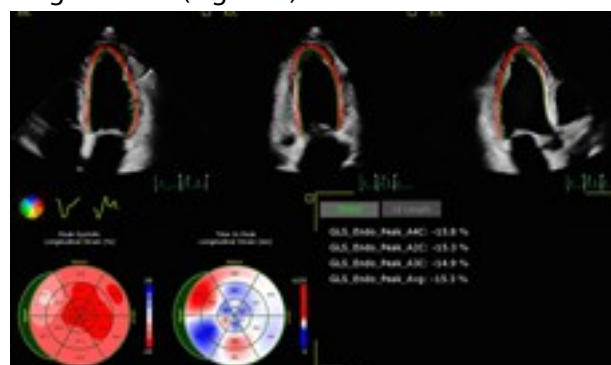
Measurement of left ventricular global longitudinal strain (GLS) using 2D speckle-tracking echocardiography
